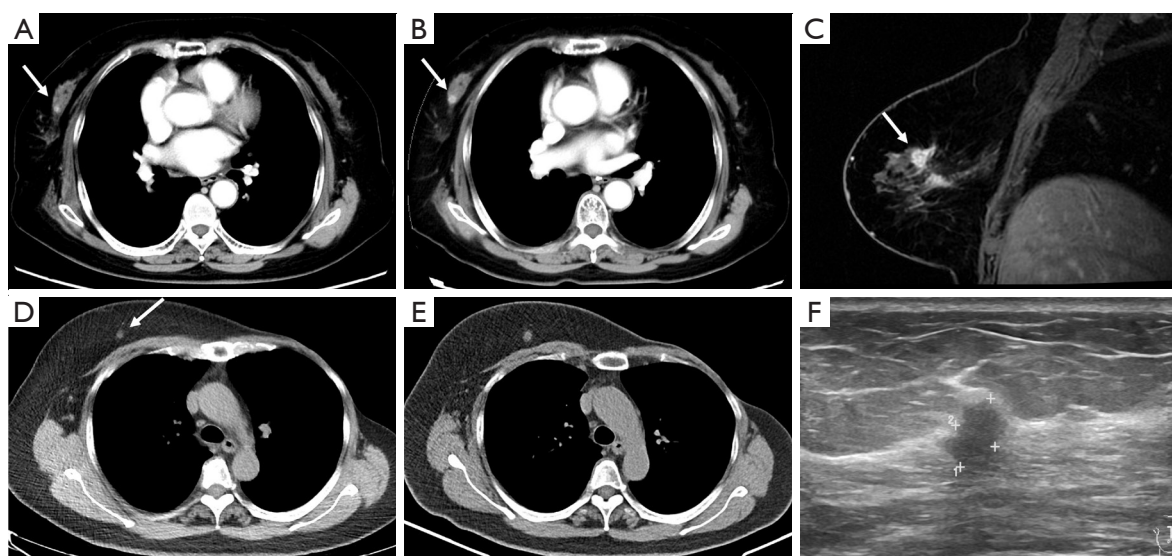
Blind spot on chest CT: breast. (A-C) A 69-year-old female after surgery for left lower lobe. A growing nodule in the right breast was ignored during the follow-up period (arrows) (A,B). Later, an irregular and abnormal enhanced mass was seen on contrast-enhanced MRI (arrow) (C), combined with its signals in different sequences, it was confirmed to be breast cancer. (D-F) A 56-year-old female after left breast cancer resection. Because of its small size, radiologists have repeatedly overlooked a small nodule in the right breast upon multiple postoperative low-dose CT exams (arrow). A retrospective review revealed that there was progressive enlargement of this right breast nodule, and ultrasound confirmed the presence of breast cancer. CT, computed tomography; MRI, magnetic resonance imaging.
